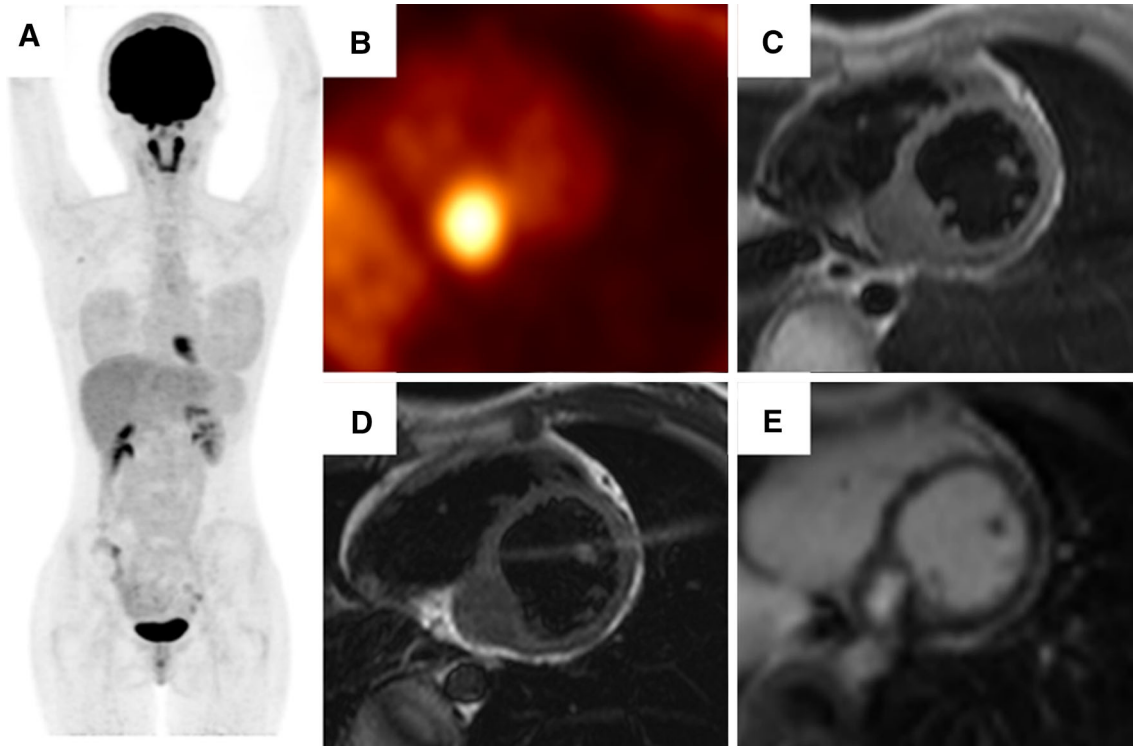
¹⁸F-fluorodeoxyglucose (FDG) positron emission tomography (PET)/computed tomography (CT) and MRI images. Maximum intensity projection (A), cardiac short-axis image (B) of the PET/CT, T1-weighted image (T1WI) (C), T2-weighted image (T2WI) (D), and late gadolinium enhancement (LGE) (E) image of the MRI are shown. FDG PET/CT showed focal tracer accumulation in the entire mass (maximum standardized uptake value was 6.8). There was no other abnormal FDG uptake. Cardiac MRI showed iso-intense on T1WI, hypo-intense on T2WI, and hyper-intense on LGE in the mass.
